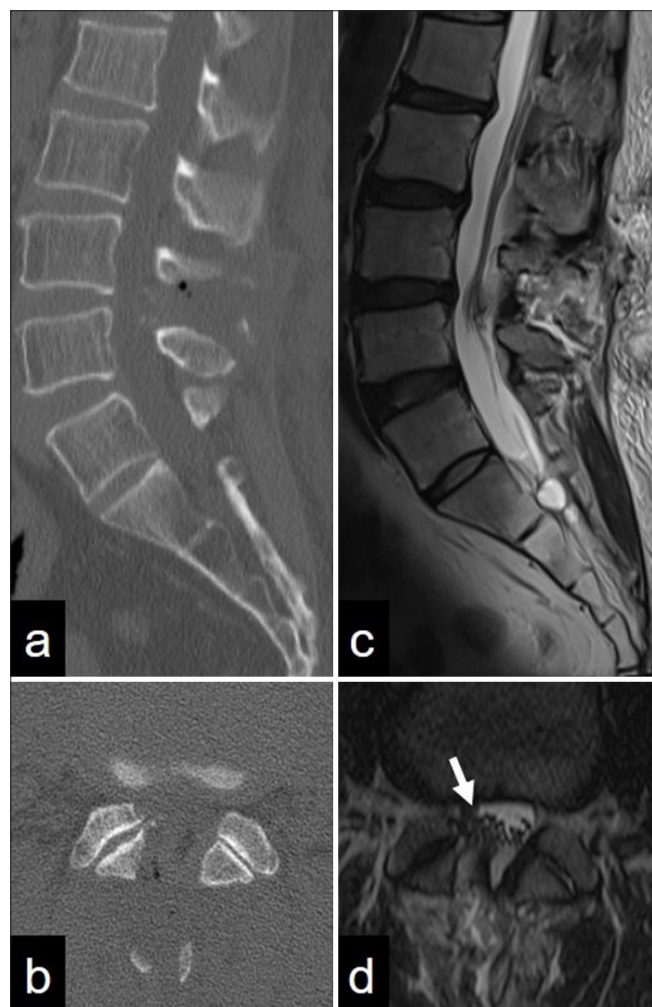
Postoperative computed tomography (a) sagittal and (b) axial images and T2-weighted magnetic resonance (c) sagittal and (d) axial images confirming the lesion was subtotally removed. Compression of the cauda equina was improved (arrow).
